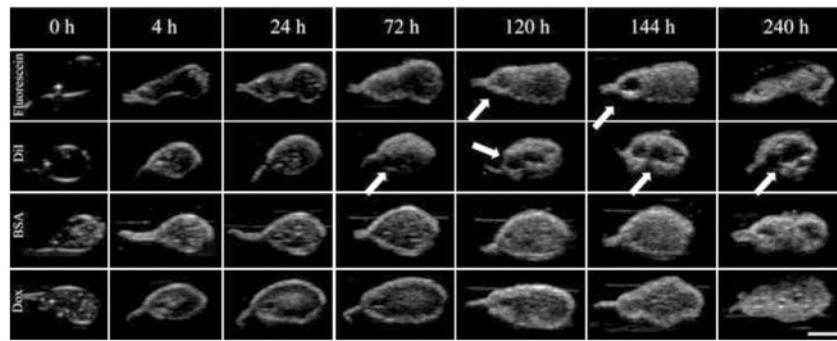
Representative gray-scale ultrasound images of implants acquired over a period of 240 h; each *row* is representative of implants loaded with different drugs: Fluorescein, DiI, BSA, and Dox. The *scale bar* represents 2.5 mm. Pore formation is indicated with *arrows*
